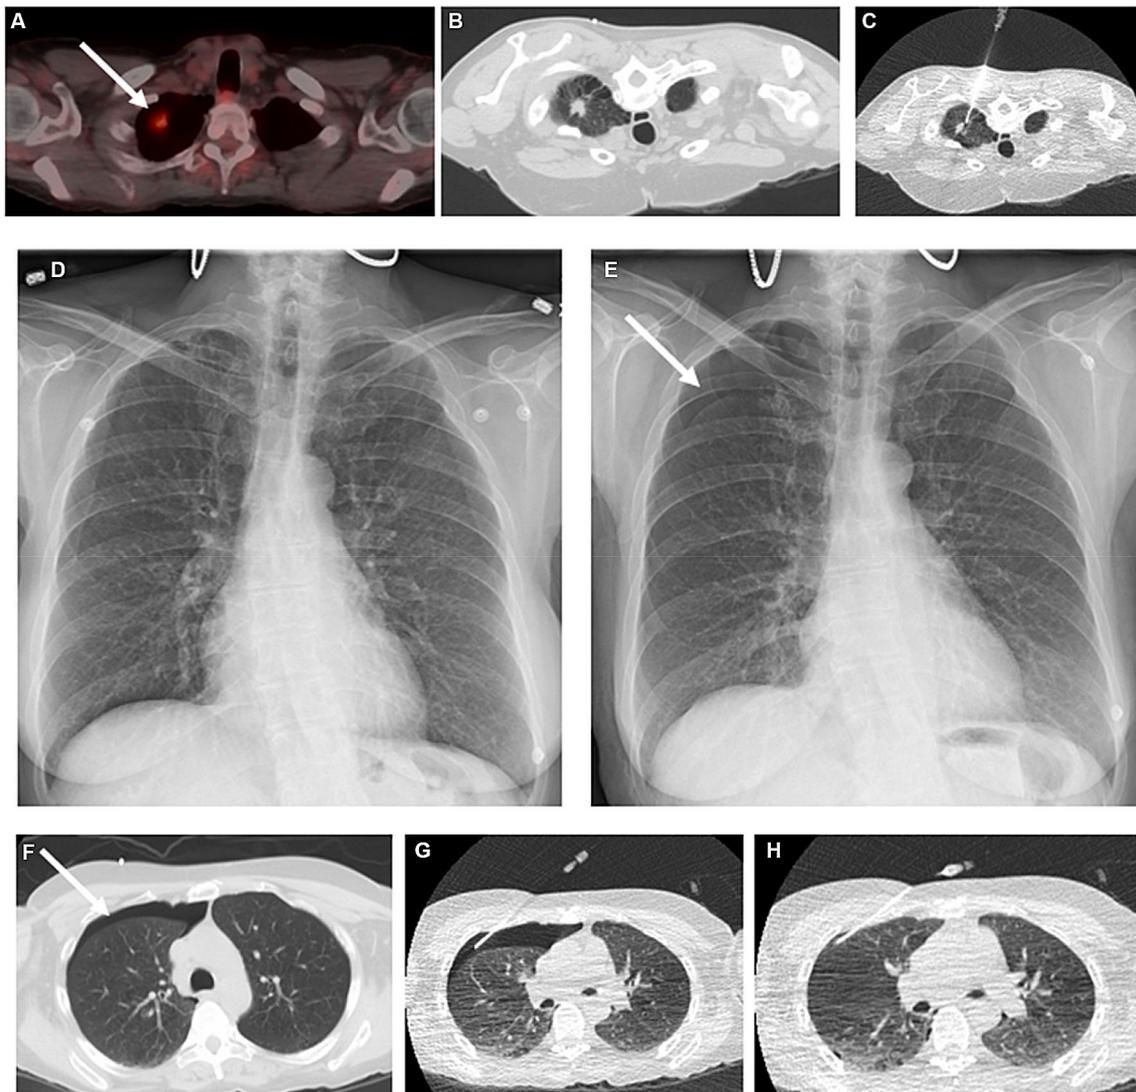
57-year-old female with spiculated FDG-avid RUL nodule seen on PET (arrow, A). Patient was placed in a prone position for CT-guided biopsy (B) which was performed with CT fluoroscopy using a co-axial technique using a 19-gauge introducer needle (C). A total of 3 core biopsy passes were taken using a 20-gauge, 1.2-cm throw core needle. Initial post-procedure chest X-ray demonstrated no pneumothorax (D). However, as the patient was leaving the department after 3 hours of observation, she developed chest heaviness. Repeat chest X-ray (E) demonstrated a small to moderate
